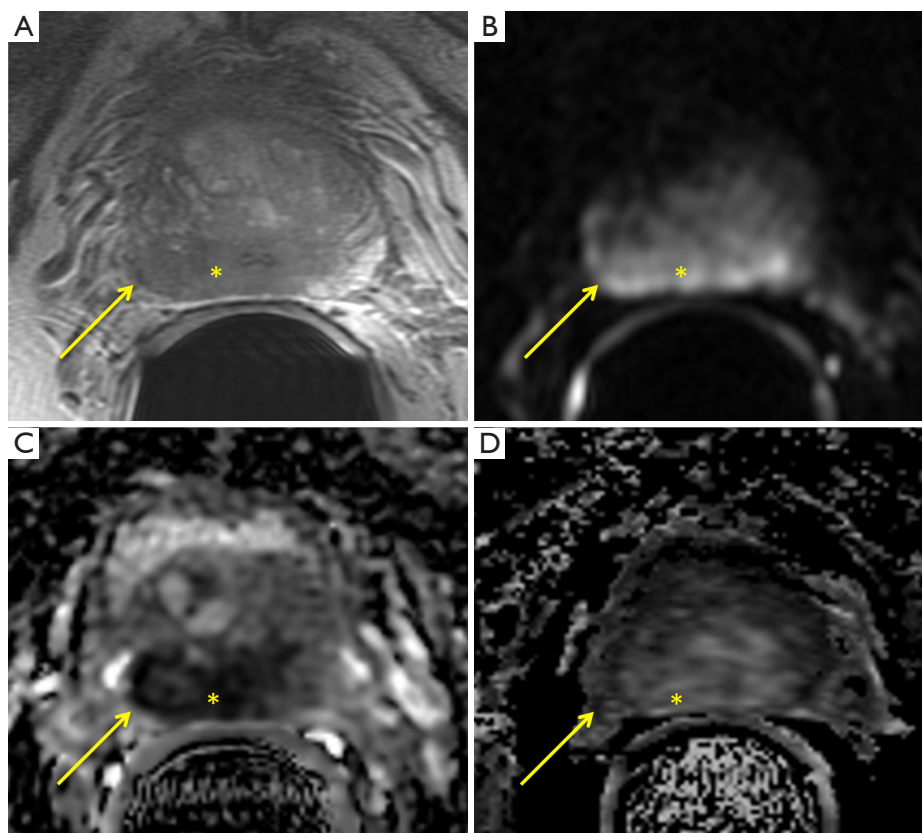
Axial T2WI, DWI, ADC map, and DCE at the midgland to base of the prostate of a 64-year-old man with biopsy proven prostate cancer (Gleason score 5+5). There is a large area of low T2 signal in the peripheral and transition zones, right greater than left side (2A, *). Extraprostatic extension (EPE) is present (arrow), as tumor is noted beyond the boundaries of the prostate. Seminal vesicle invasion is also present bilaterally (not shown). DWI demonstrates increased signal (2B, asterisk), which is confirmed with low values on the ADC map (2C, *). DCE demonstrates rapid contrast uptake at the region of low signal on T2WI and ADC map (2D, *). T2WI, T2-weighted image; DWI, diffusion-weighted MR imaging; ADC, apparent diffusion coefficient; DCE, dynamic contrast-enhanced.
